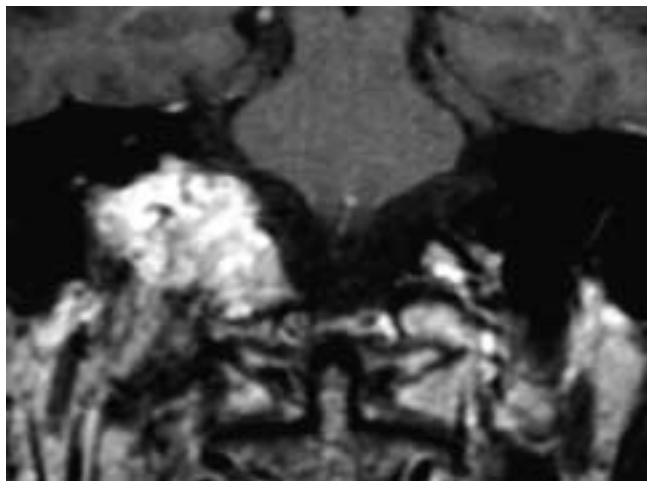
Coronal T2-weighted MR image shows a mass centered in the right jugular fossa. This glomus jugulare tumor has high signal intensity and serpiginous areas of signal void. Laterally, the tumor extends into the middle ear, and the lesion extends about as much into the posterior fossa as it does below the skull base.
